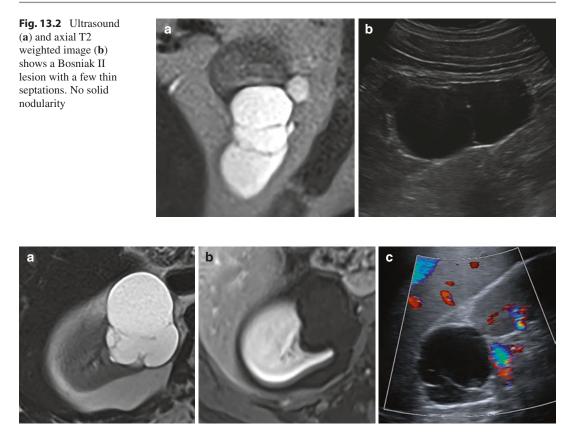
Bosniak IIF cyst on axial T2 weighted image (a) shows mildly thickened and complex septations without measureable enhancement on post contrast MRI (b) and no internal vascularity on ultrasound (c)
